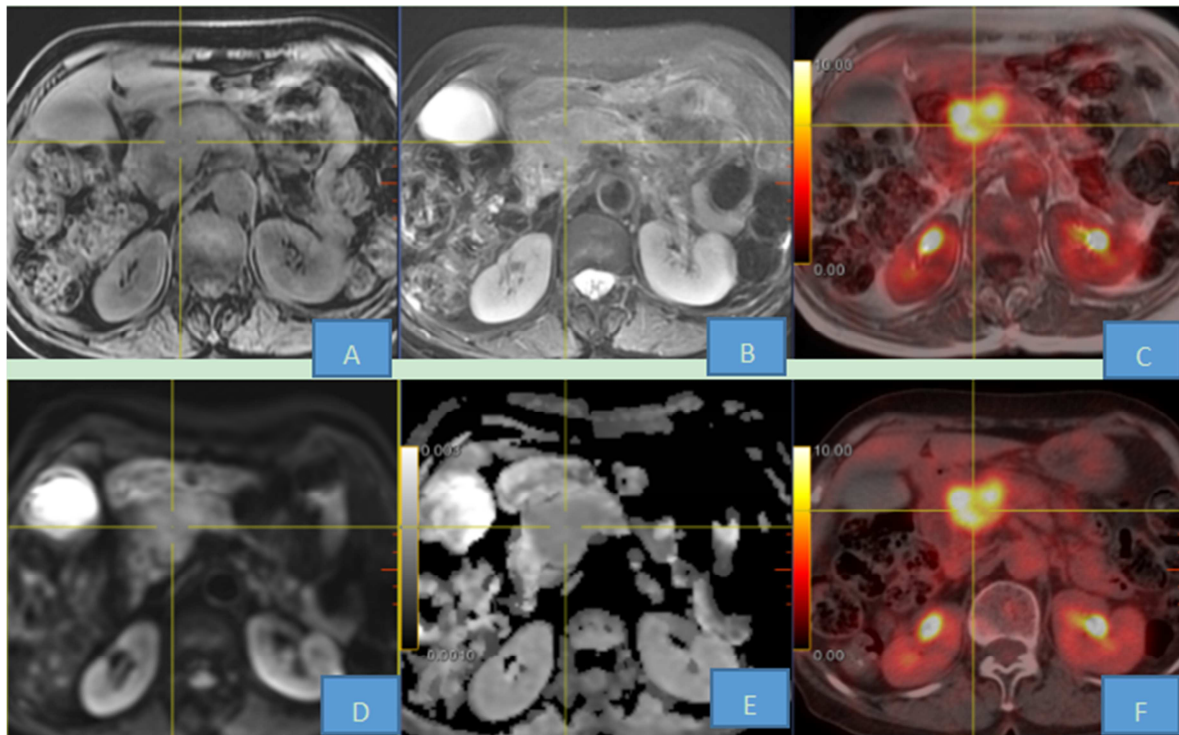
Typical cases of PET-CT and MRI fusion images.
